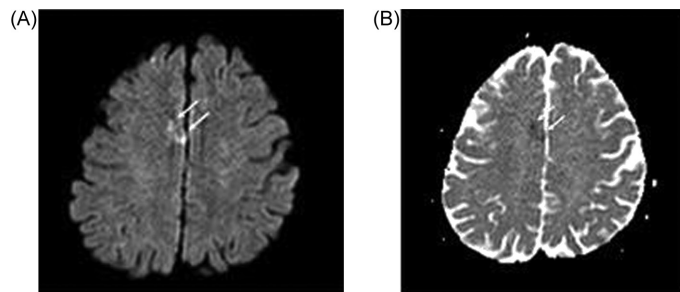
Postinterventional cranial diffusion-weighted magnetic resonance imaging (A) shows an anterior cerebral artery territory with a high signal intensity lesion (arrow). On apparent diffusion coefficient (ADC) map (B), the lesion shows low signal intensity (arrow) indicating its acute nature.
